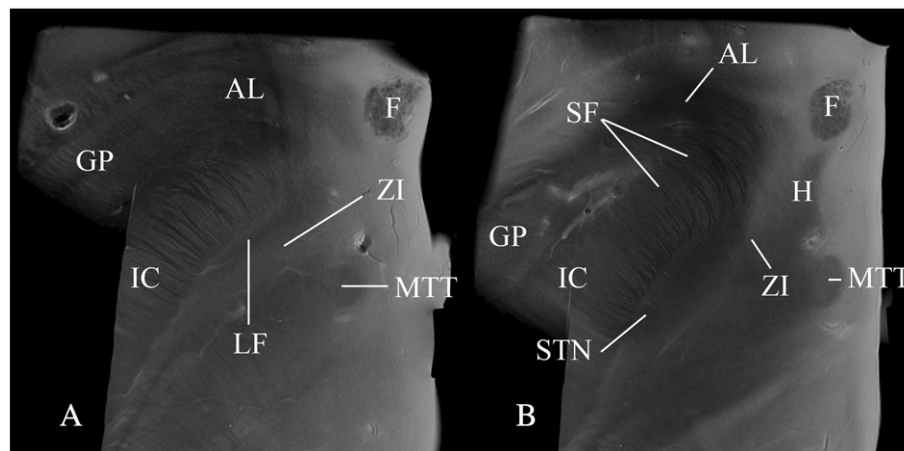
The STN in the axial plane using SE MRI with image resolution acquired at 44 μm in plane. Panel A just above the level of the STN, Panel B at a superior level of the STN above the RN. The resolution of these images allows clear identification the fibres of the subthalamic fasciculus radiating through the internal capsule.
